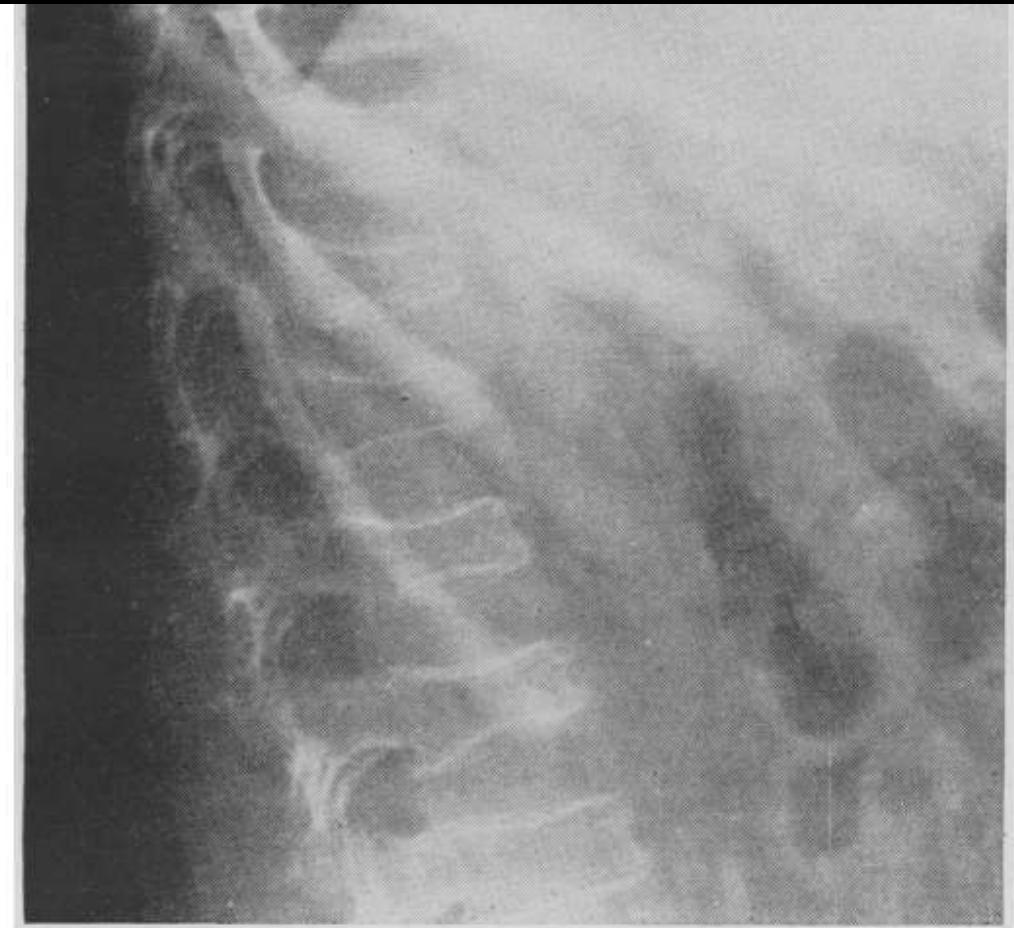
Roentgenogram showing lateral view of the dorsolumbar spine of the patient reported on in case 3. Multiple compression lesions of the vertebral bodies with marked osteoporosis are seen.
